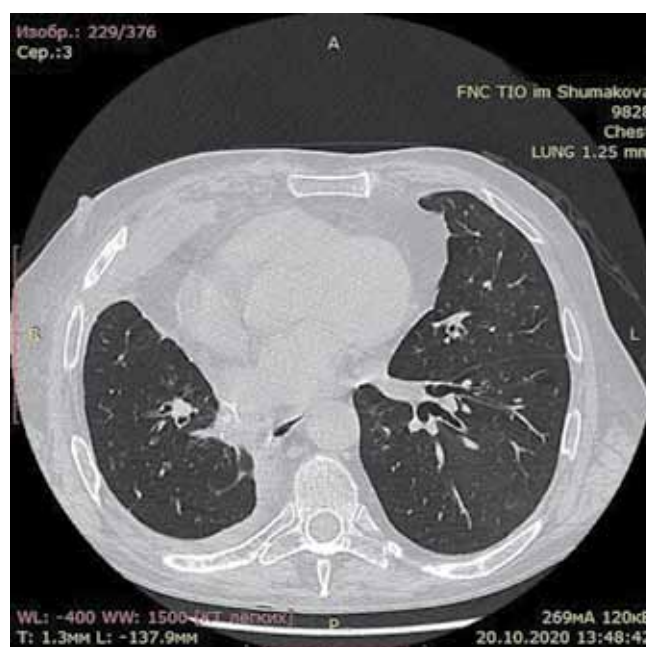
Multispiral CT scan 2.5 months after surgery
